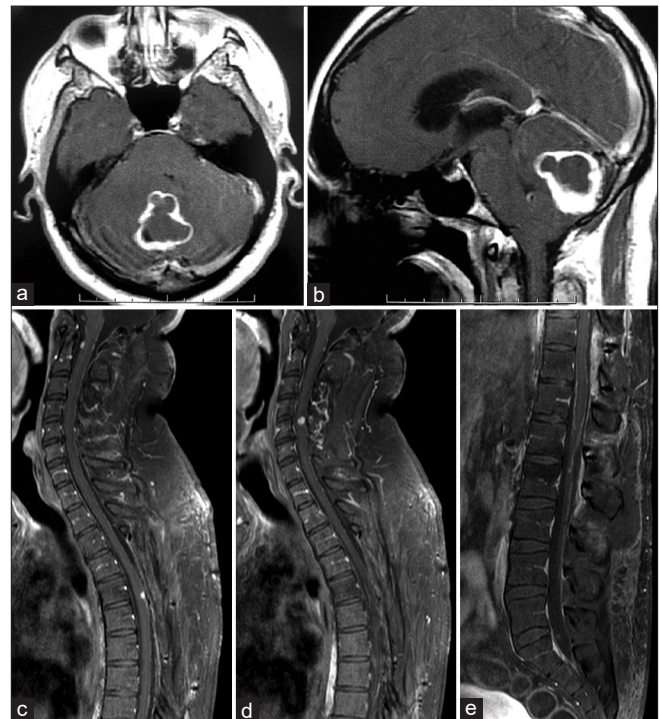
Gadolinium-enhanced T1-weighted axial (a) and sagittal (b) MRI showing a midline lesion in the posterior fossa with peripheral contrast enhancement in January 2011. Gadolinium-enhanced sagittal T1-weighted MRI showing multiple intradural extramedullary spinal lesions at C1, Th5 (c), and C5 (d), with leptomeningeal enhancement (e) in July 2019.
